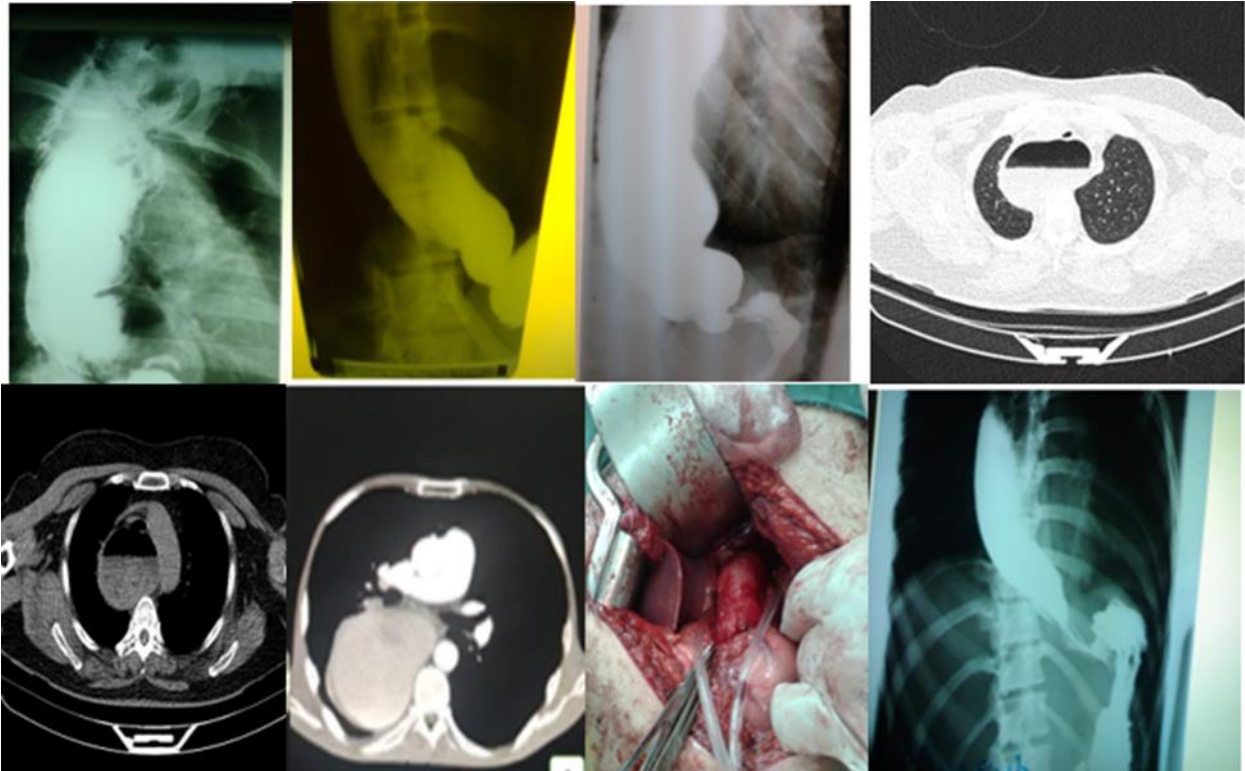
Barium swallow with sever dilation, CT-scan of chest with sever dilation, cardio myotomy, show post operative barium swallow 8-month latter.
